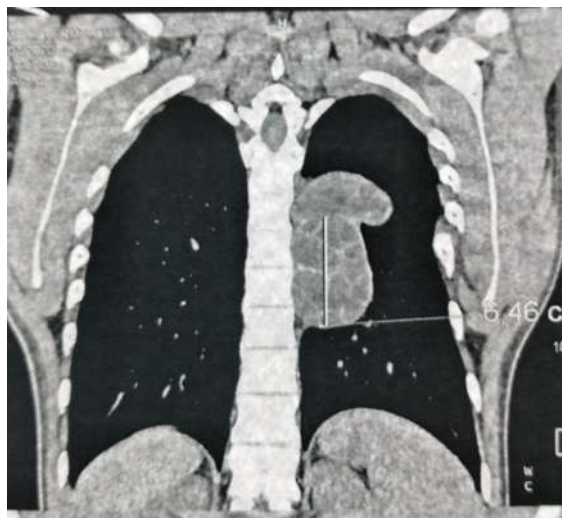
Coronal thoracic CT section, mediastinal window showing a paravertebral multi-vesicular cystic formation
